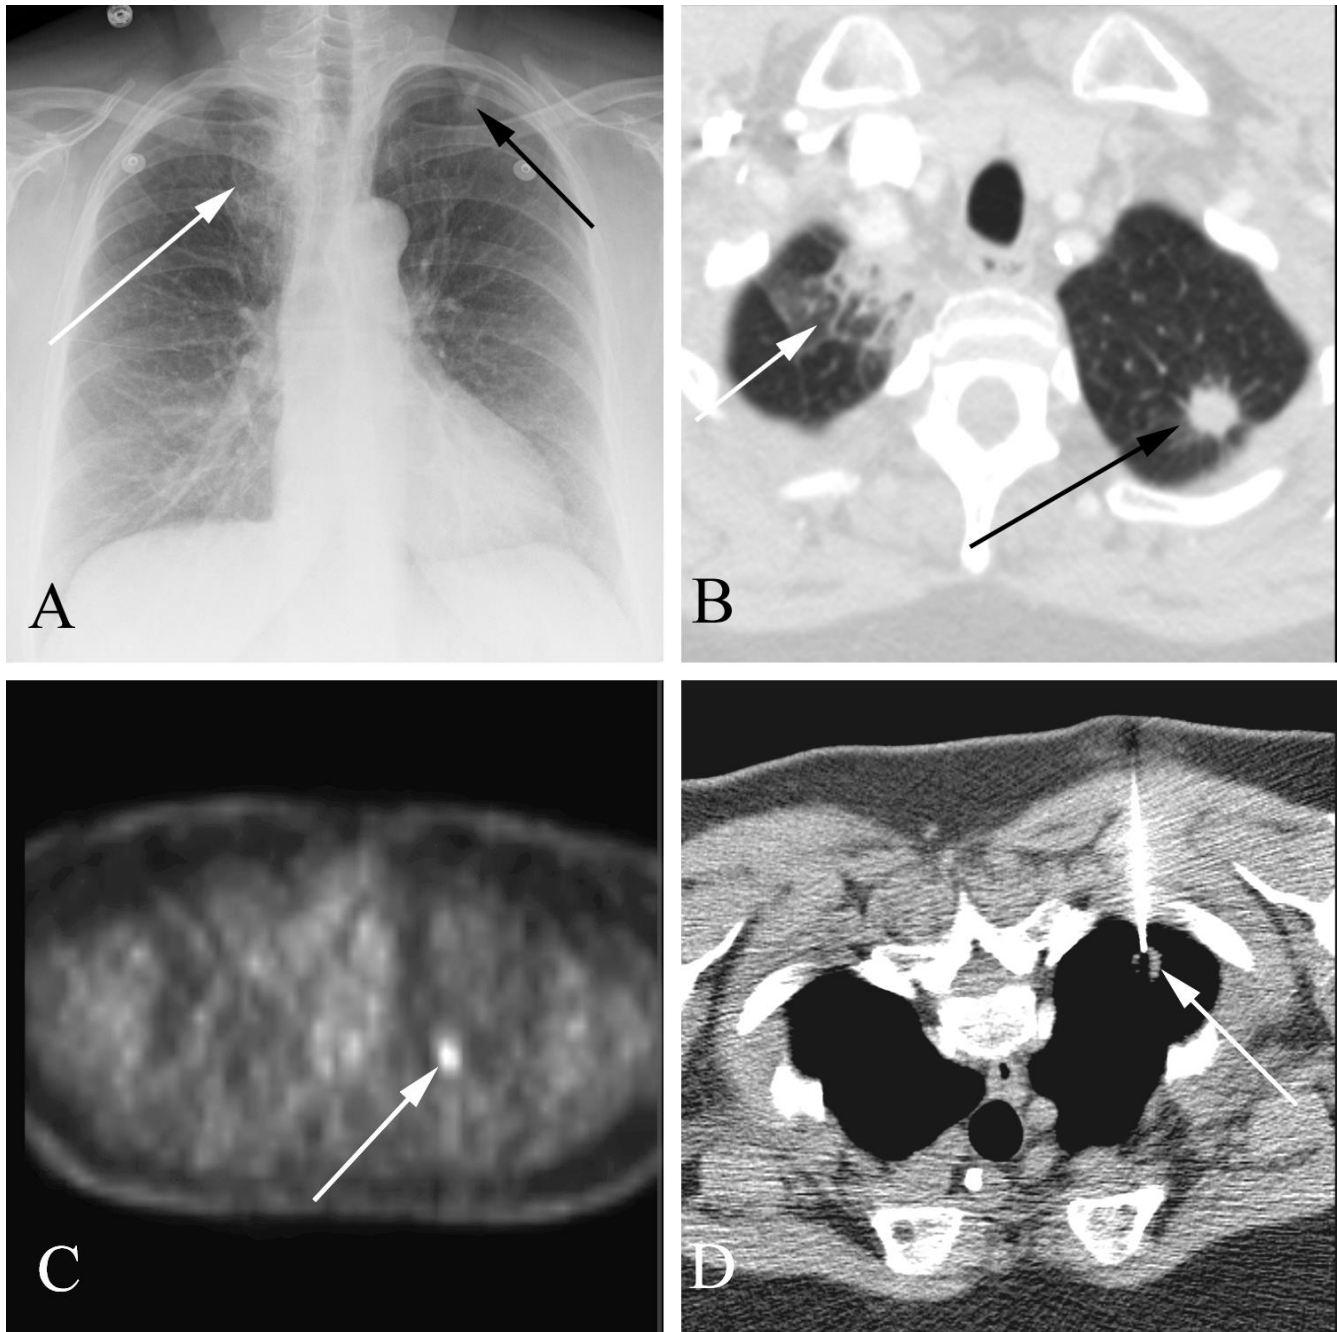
Adenocarcinoma in a 63 year old woman with pneumonia. A. Chest radiograph shows right upper lobe pneumonia (white arrow) and a contralateral left upper lobe pulmonary nodule (black arrow). B. CT study shows the pneumonia (white arrow) and the pulmonary nodule (black arrow). C. PET scan shows hypermetabolism at the location of the nodule (white arrow). D. A CT directed biopsy with the needle in the lesion (arrow). Adenocarcinoma was found at pathology.
